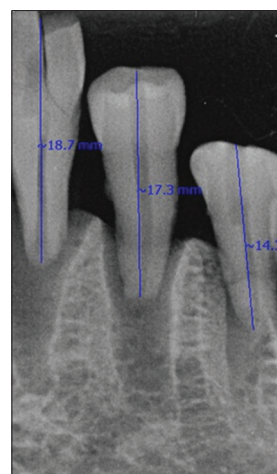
Periapical view of mounted teeth with working length measurement.
